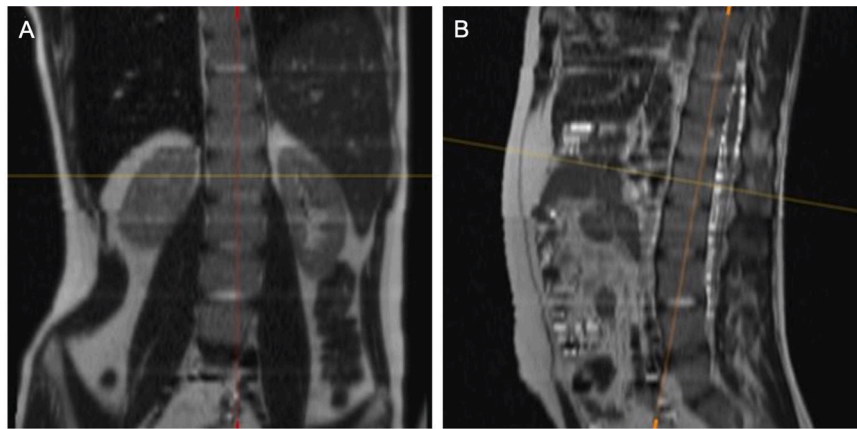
Magnetic resonance imaging scans in the frontal plane (A) and median plane (B).
